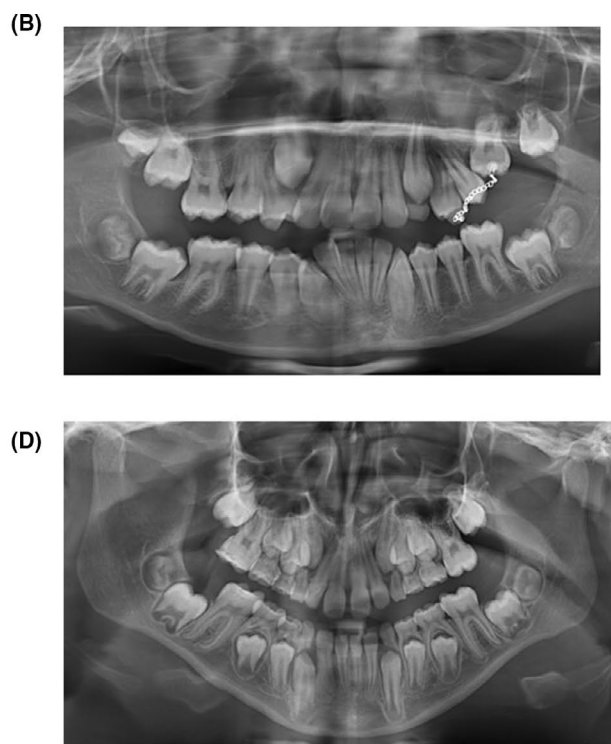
Clinical photographs and radiographs of systemically healthy control patient diagnosed with gingivitis (A,B) and periodontal health (C,D)
